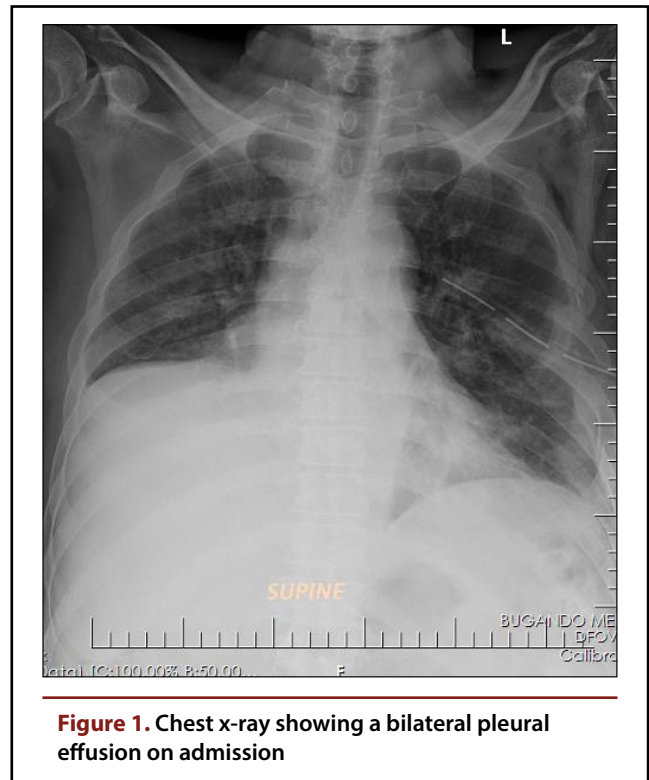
Chest x-ray showing a bilateral pleural effusion on admission
